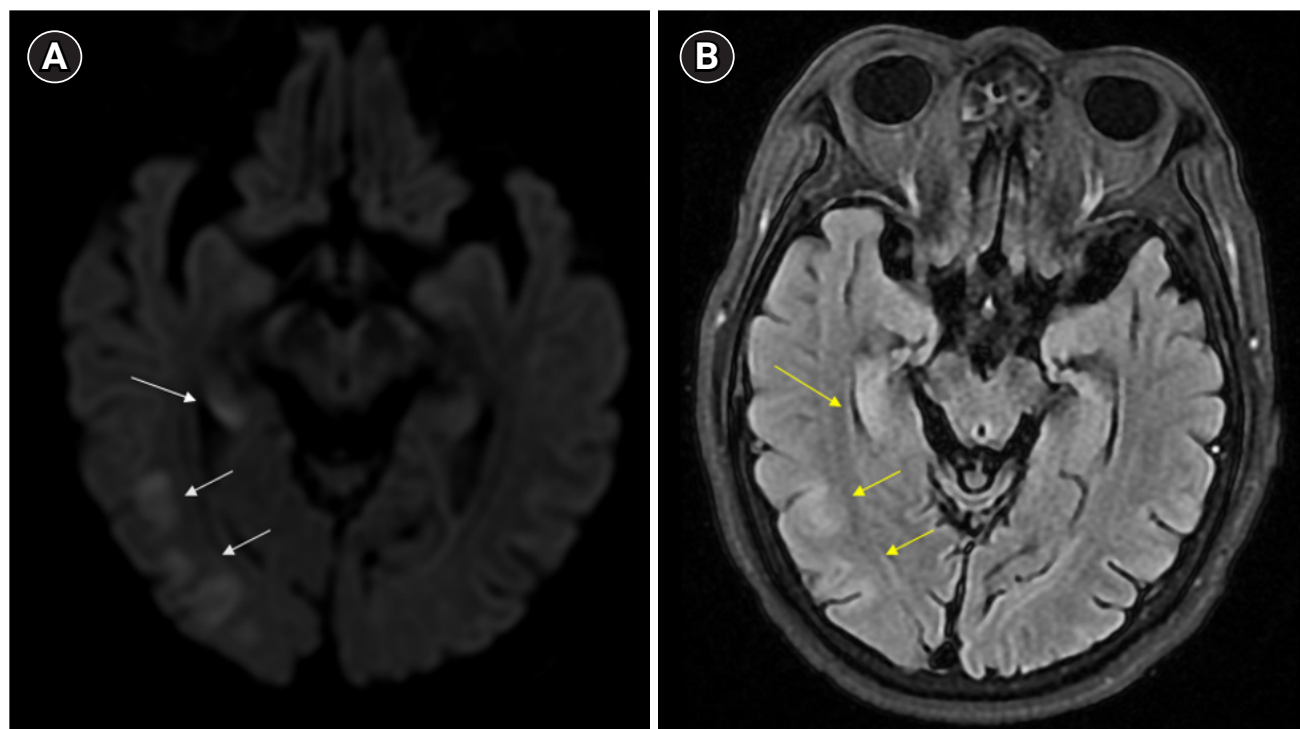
Brain magnetic resonance imaging. Diffusion-weighted image (A) displaying high signal intensities in the right hippocampal, limbic, and parieto-occipital cortices (white arrows). The fluid attenuated inversion recovery (B) exhibits high signal intensity in the same region (yellow arrows).
